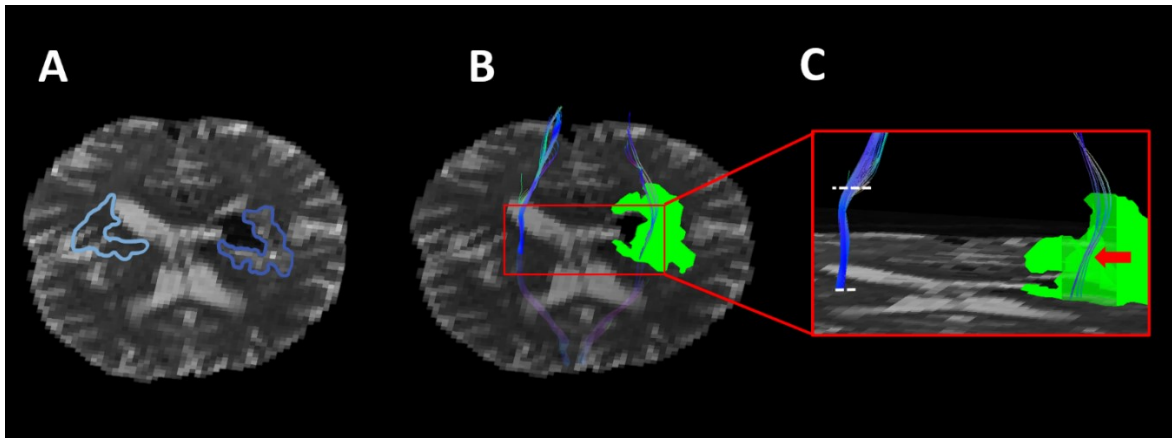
Measurement of Fractional Anisotropy (FA) in the edema and Corticospinal Tract (CST). Regions of interest are shown on the T2-weighted ‘Mean of $b=0$ s/mm²’ map. A) FA was measured in the perihematoma edema (dark blue) and contralateral area (light blue). B) The three-dimensional CST was overlapped with the mask of the edema (green). C) FA was measured in the portion of the CST passing through the edema (arrow), and in the portion of contralateral CST parallel to the edematous CST (dotted line).
